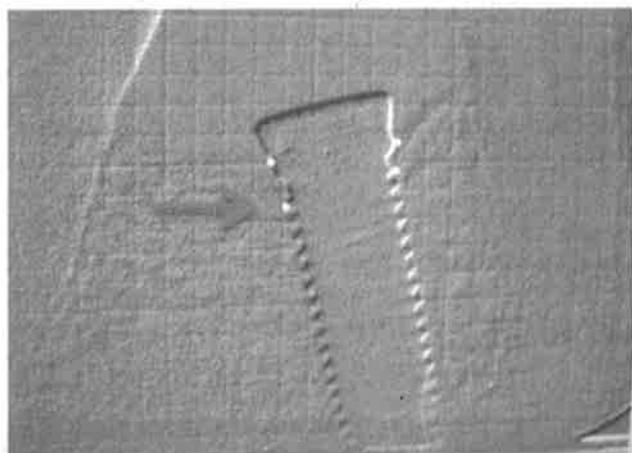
Computer-assisted measurement of digitalized radiograph showing reference points for bone level.
